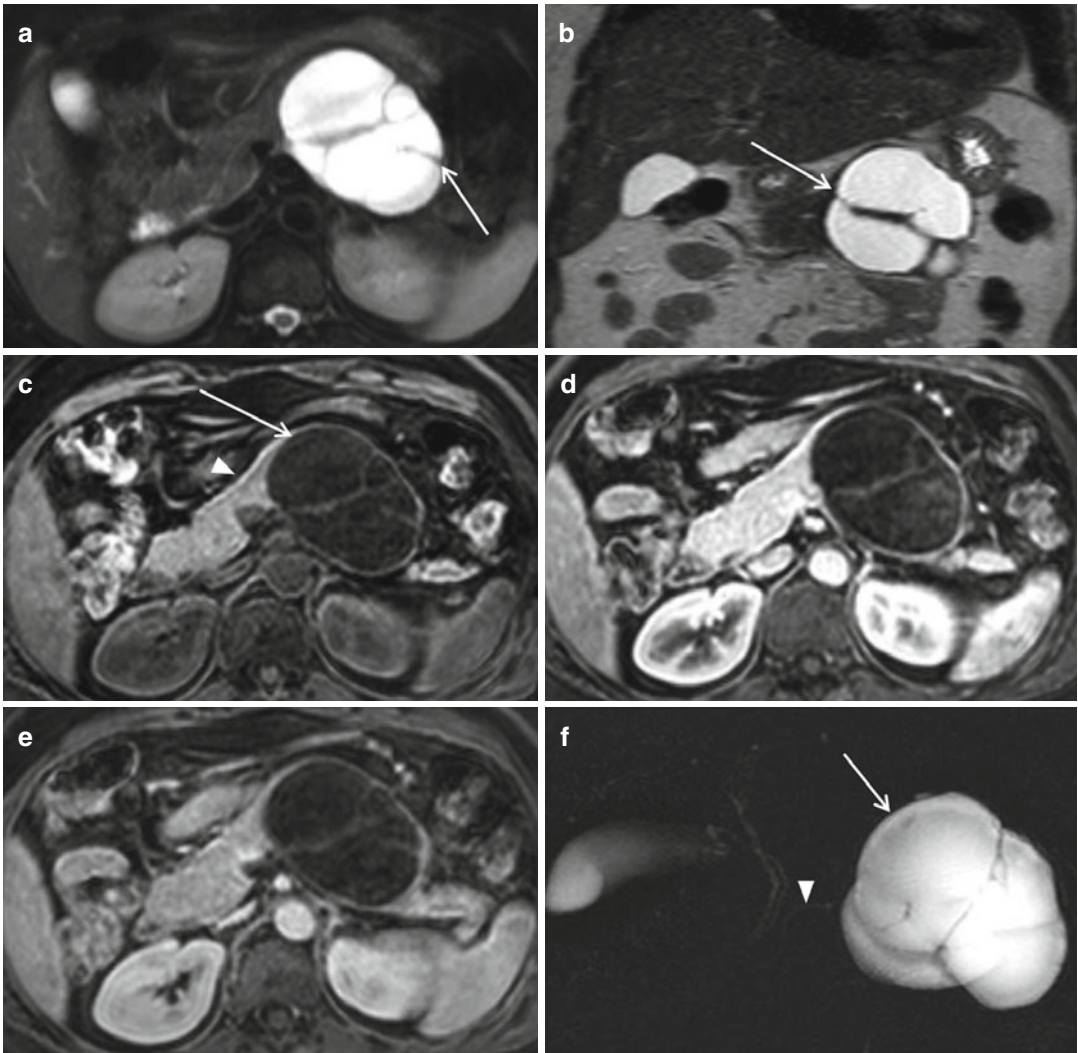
A 76-year-old female patient with mucinous cystadenoma in the body-tail of the pancreas. (a, b) Axial (a) and coronal (b) T2-weighted images: a hyperintense cystic mass with septa (*arrow*) is visible. (c) Axial T1-weighted GRE image with fat saturation: the content of the lesion (*arrow*) is homogeneously hypointense compared to the adjacent pancreatic parenchyma (*arrowhead*)
